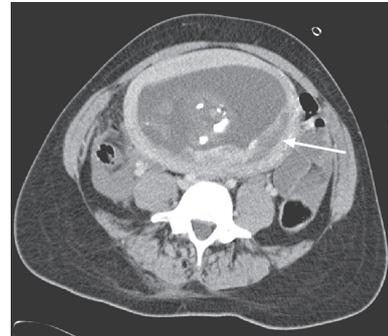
Post contrast CT of the lower abdomen showing the gravid uterus with placental abruption.
